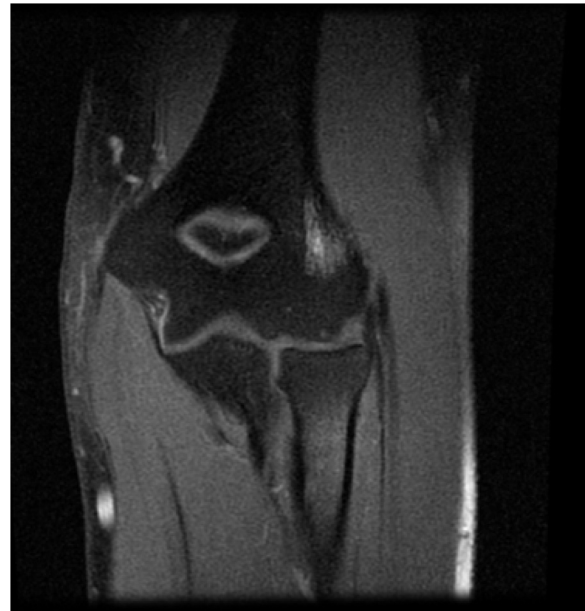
A follow-up MRI of the left elbow after 12 months of treatment showing improvement of the osteomyelitis in the left humerus.
